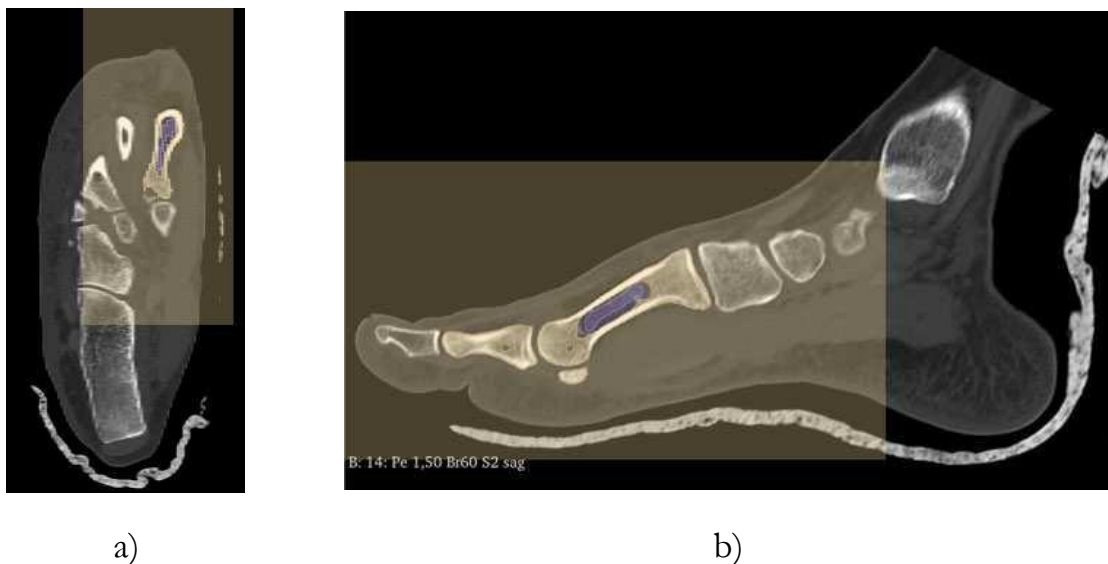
CT visualization with selection of the region to be segmented: a) CT top view; b) Lateral CT view.
